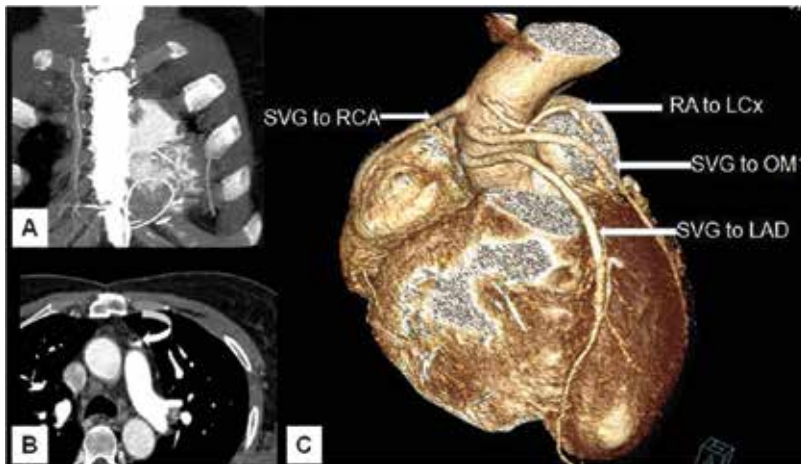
A 72-year-old male patient who was operated 10 years earlier with four grafts: left internal mammary artery graft to left anterior descending artery (LIMA to LAD), saphenous vein graft to right coronary artery (SVG to RCA), radial graft to left circumflex artery (RA to LCx), and SVG to first obtuse marginal (SVG to OM1). Because of an occlusion of LIMA to LAD graft and typical chest pain, redo-bypass graft surgery was performed 4 years ago with SVG to LAD to revascularize LAD. Post second operation CTA was performed because of atypical chest pain. Coronal (panel A) and axial (panel B) images showed absent LIMA with occlusion of the old LIMA to LAD graft (curved arrow). VRT image (panel C) showed patent all old and new venous grafts, but the arterial graft (RA to LCx) is occluded midway between its origin and distal anastomosis.
